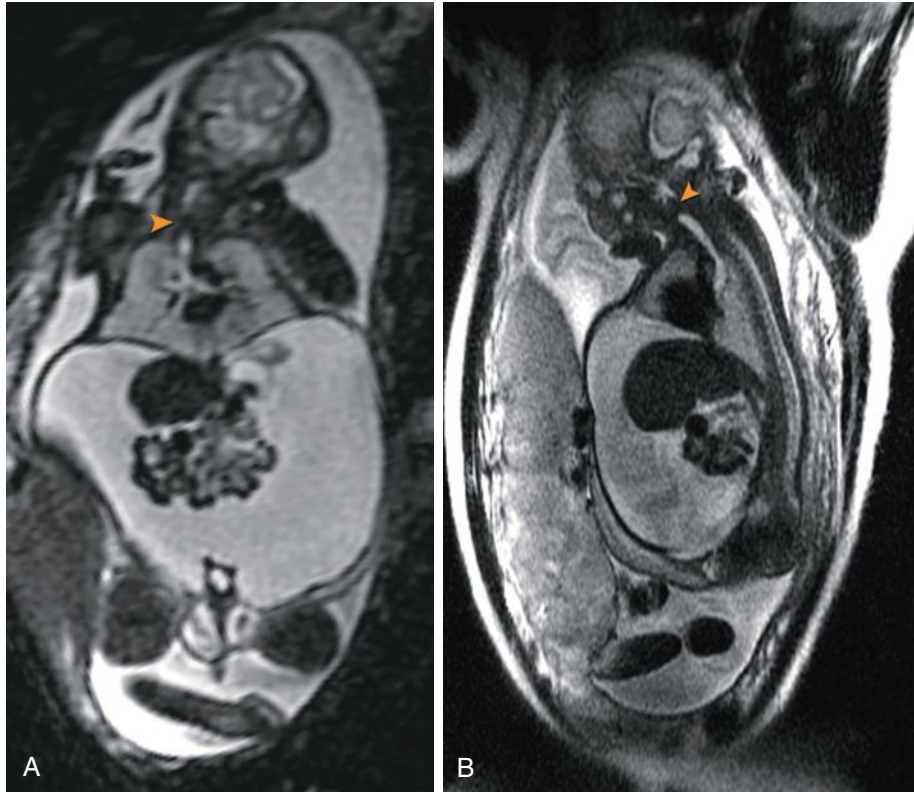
Congenital high airway obstruction syndrome (CHAOS) at 23 weeks' gestation. T2-weighted coronal (A) and sagittal (B) images demonstrate bright lungs, bell-shaped thorax, and large volume of ascites. The dilated fluid-filled trachea can be seen distal to the laryngeal obstruction (*arrowhead*).
